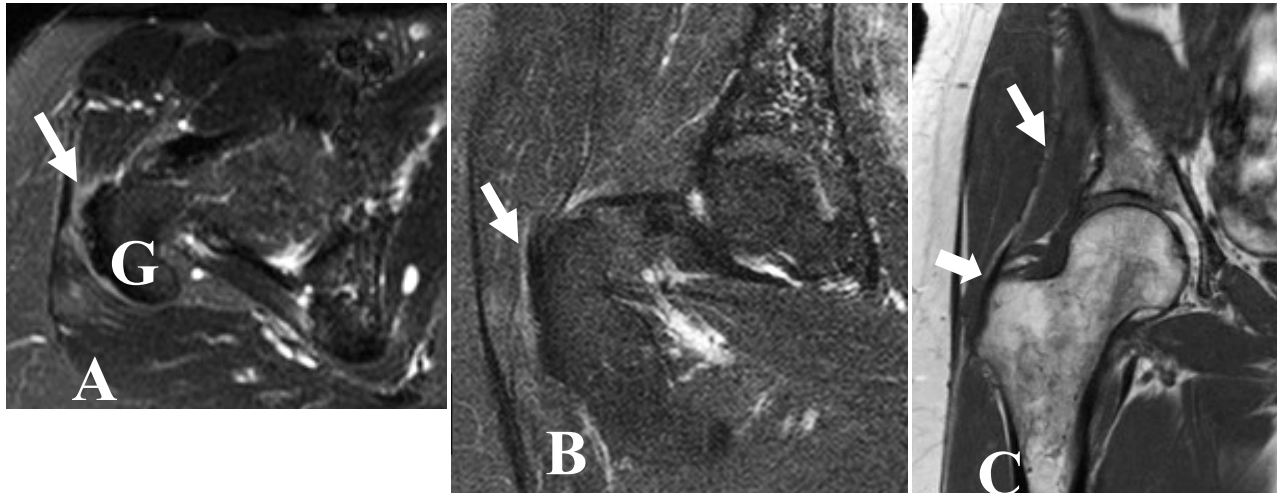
Conventional MRI in a 64-year-old asymptomatic woman’s right hip, identified by both readers as an asymptomatic volunteer. Axial STIR image shows hyperintensity (arrow) adjacent to the greater trochanter (G). Both readers identified this finding as a grade 1 lesion (T2 hyperintensity) of the greater trochanteric bursa. b Coronal fat-suppressed T2-weighted image demonstrates the lateral gluteus medius tendon attaching to the lateral facet of the greater trochanter (thin arrow). One reader diagnosed a lateral gluteus medius grade 1 lesion (tendinosis) whereas the other reader indicated a normal tendon (grade 0). c Coronal T1-weighted image depicts the gluteus minimus muscle (thin arrow) and tendon (thick arrow). Both readers graded the gluteus minimus muscle and tendon as normal (grade 0).
